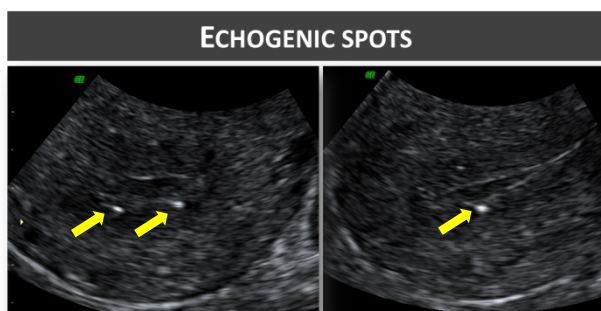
Ultrasound images showing a) myometrial cysts (yellow arrow) b) hyperechogenic islands (surrounded by green dotted lines), and c) echogenic spots (yellow arrows).
